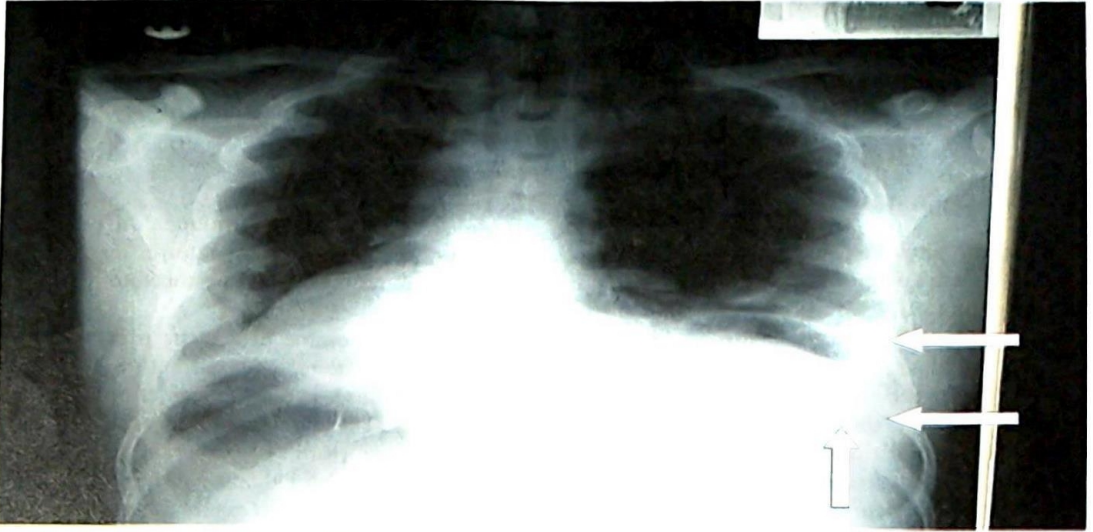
Preoperative plain chest radiograph showing dextrocardia, air under the left hemi-diaphragm ( single arrow) blunting of the left costo-phrenic angle and left sided rib fracture (double arrows) and the gastric bubble on the right.
